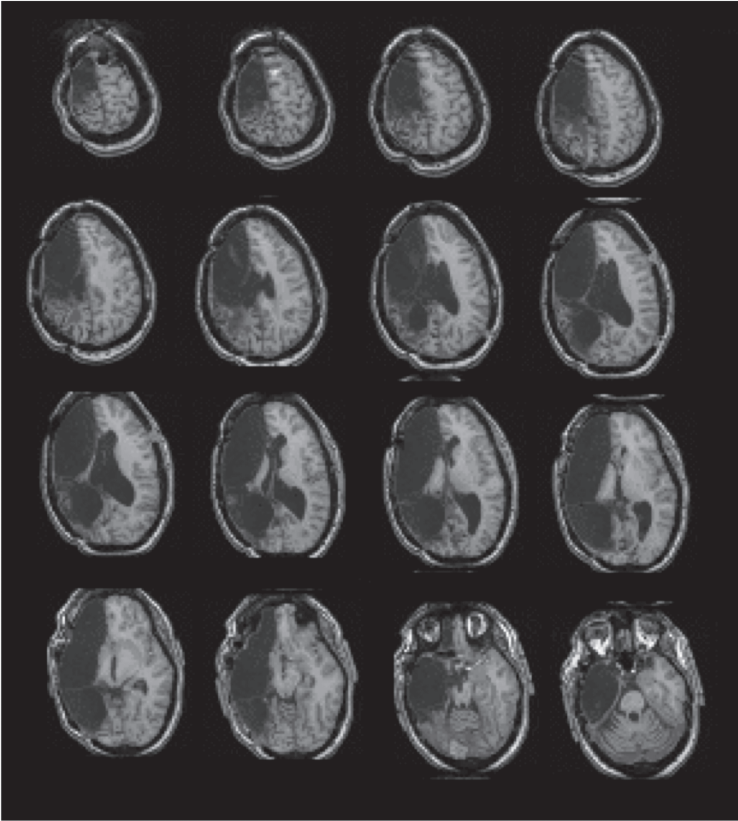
An MRI scan of Lisa’s brain, showing that her left hemisphere is mostly missing, replaced by cerebrospinal fluid.
